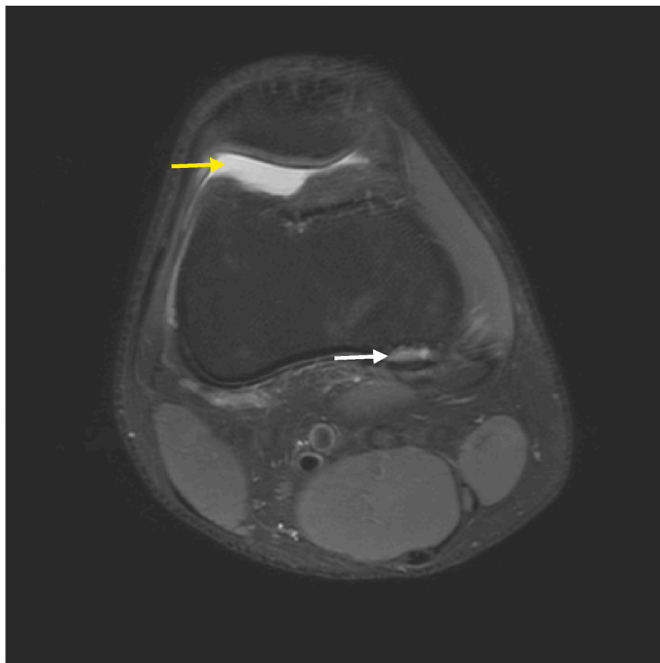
Axial fat-saturated proton density-weighted MRI scan in a 19-year-old female with distal femoral cortical irregularity (DFCI) displaying a lobulated pattern (white arrow). The patient sustained an injury while playing football and presented with knee locking and pain. Joint effusion was observed (yellow arrow).
